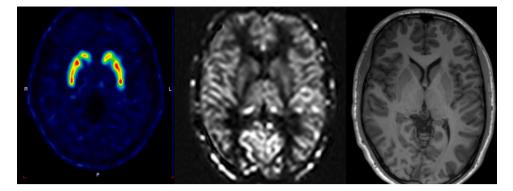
Representative example of a [¹¹C]-Raclopride PET (23 frame average), reconstructed ASL MRI perfusion image and T1 anatomical MRI of a subject.
